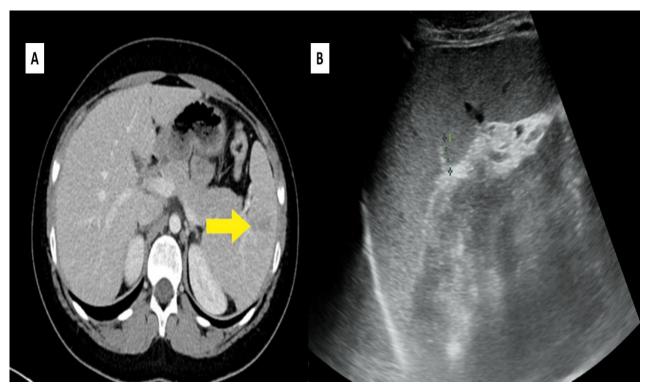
Case number1.A19-year-old male presented complaining of mild left-sided abdominal pain after falling from a motorbike on the left side of his body. A: Axial view of contrast-enhanced CT of abdomen, suggesting grade 2splenic lacerations showing multiple linear hypo-density extending from the splenic hilum reaching up to 2.5 cm; B: FAST scanning may be performed and revealed disruption to the splenic echotexture indicating laceration.
